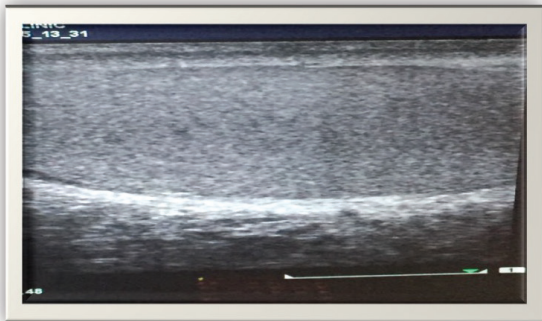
Ultrasound image of Normal testis.
